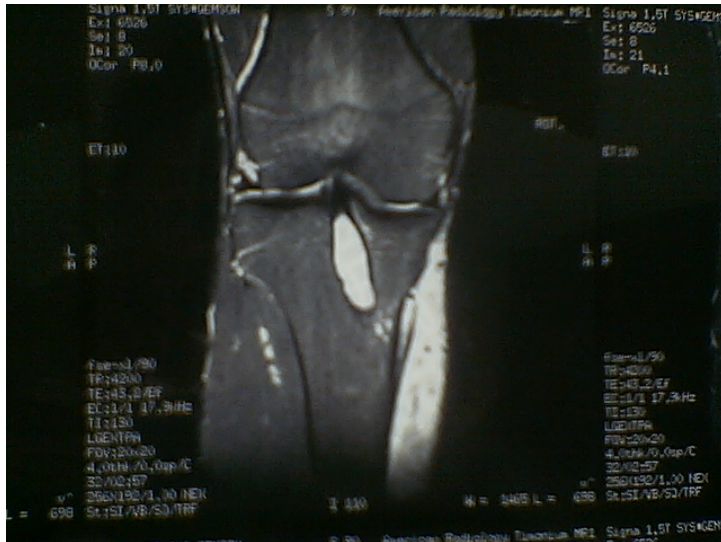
Magnetic resonance image (sagittal view) revealing fluid inside the tibial tunnel.
